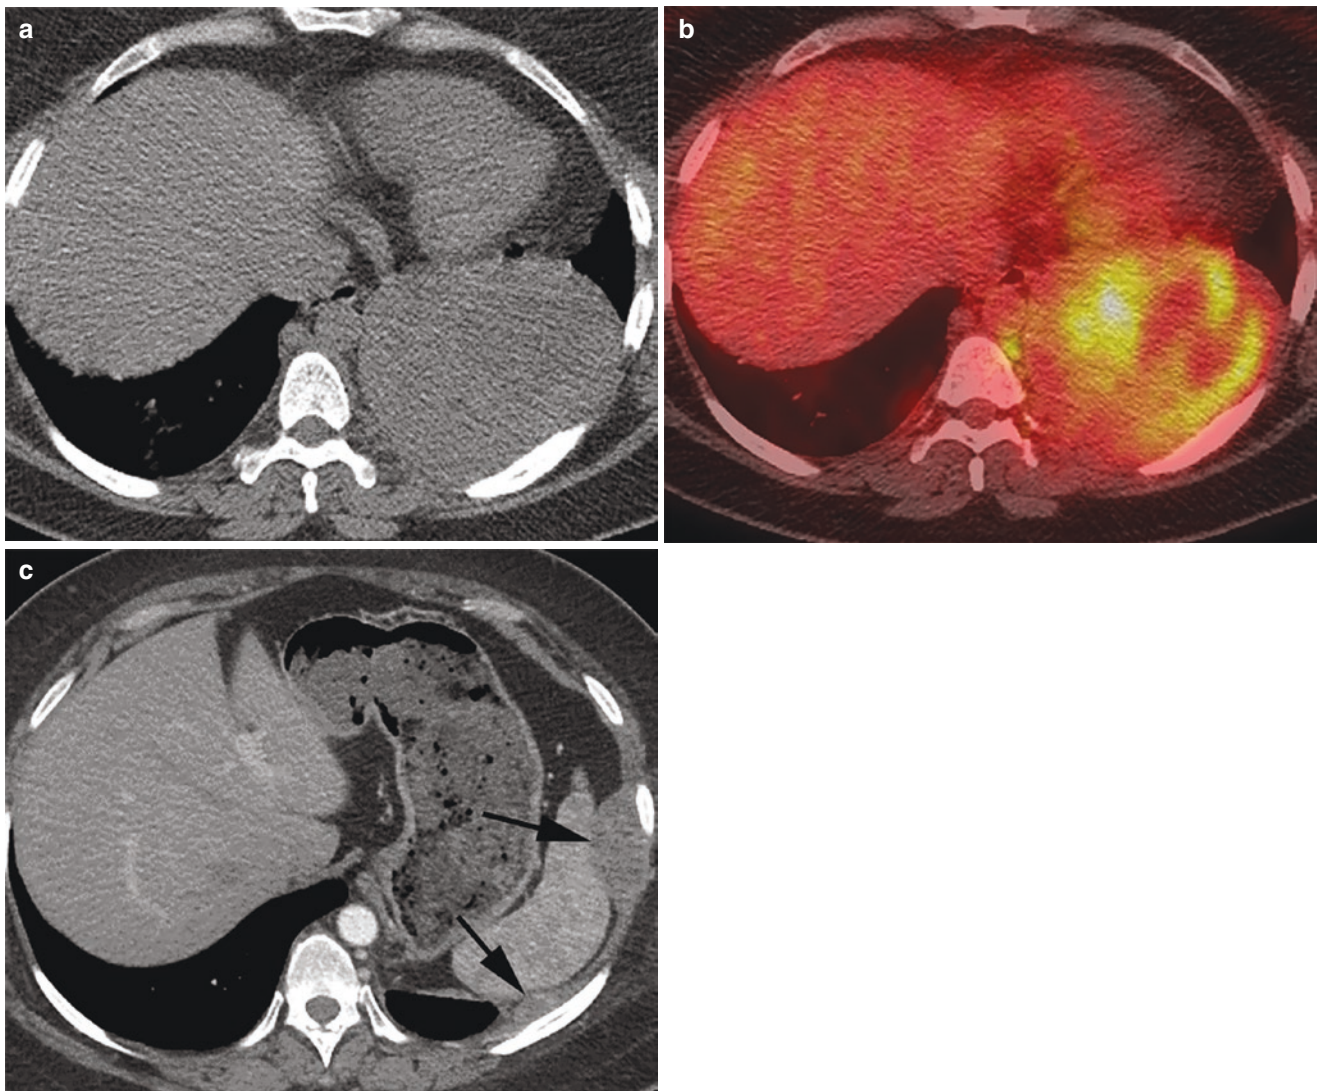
(a) Axial CT shows soft tissue mass in the left lower hemithorax, (b) axial FDG PET/CT shows FDG avidity within the mass, (c) contrast-enhanced CT 1 year after resection shows new nodules along
